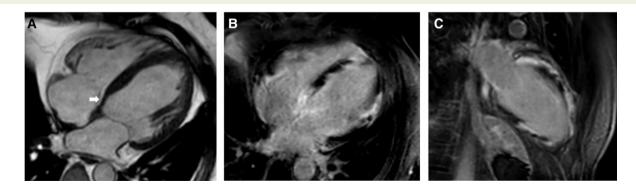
Magnetic resonance images of a patient with 3rd degree atrioventricular block and depressed left ventricular function; cardiac sarcoidosis was verified by endomyocardial biopsy. (A) apical 4-chamber cine image showing basal septal thinning (arrow) and thickened mid-septum. (B and C) apical 4- and 2-chamber images, respectively, of late gadolinium enhancement showing patchy left ventricular involvement.
